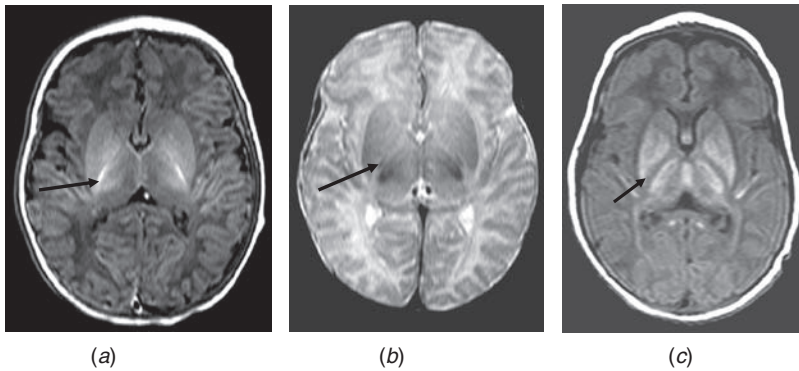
The posterior limb of the internal capsule (PLIC). (a) T1-weighted and (b) T2-weighted images in the transverse plane. Normal appearances of the neonatal brain in a term-born neonate. There is evidence of myelination within the PLIC seen as high signal intensity in (a) and less obvious low signal intensity in (b) (arrows). (c) T1-weighted image: abnormal appearances in a term-born neonate with severe basal ganglia and thalamic injury. There is no high signal from myelin within the PLIC, which has a uniform abnormal low signal intensity (arrow).
